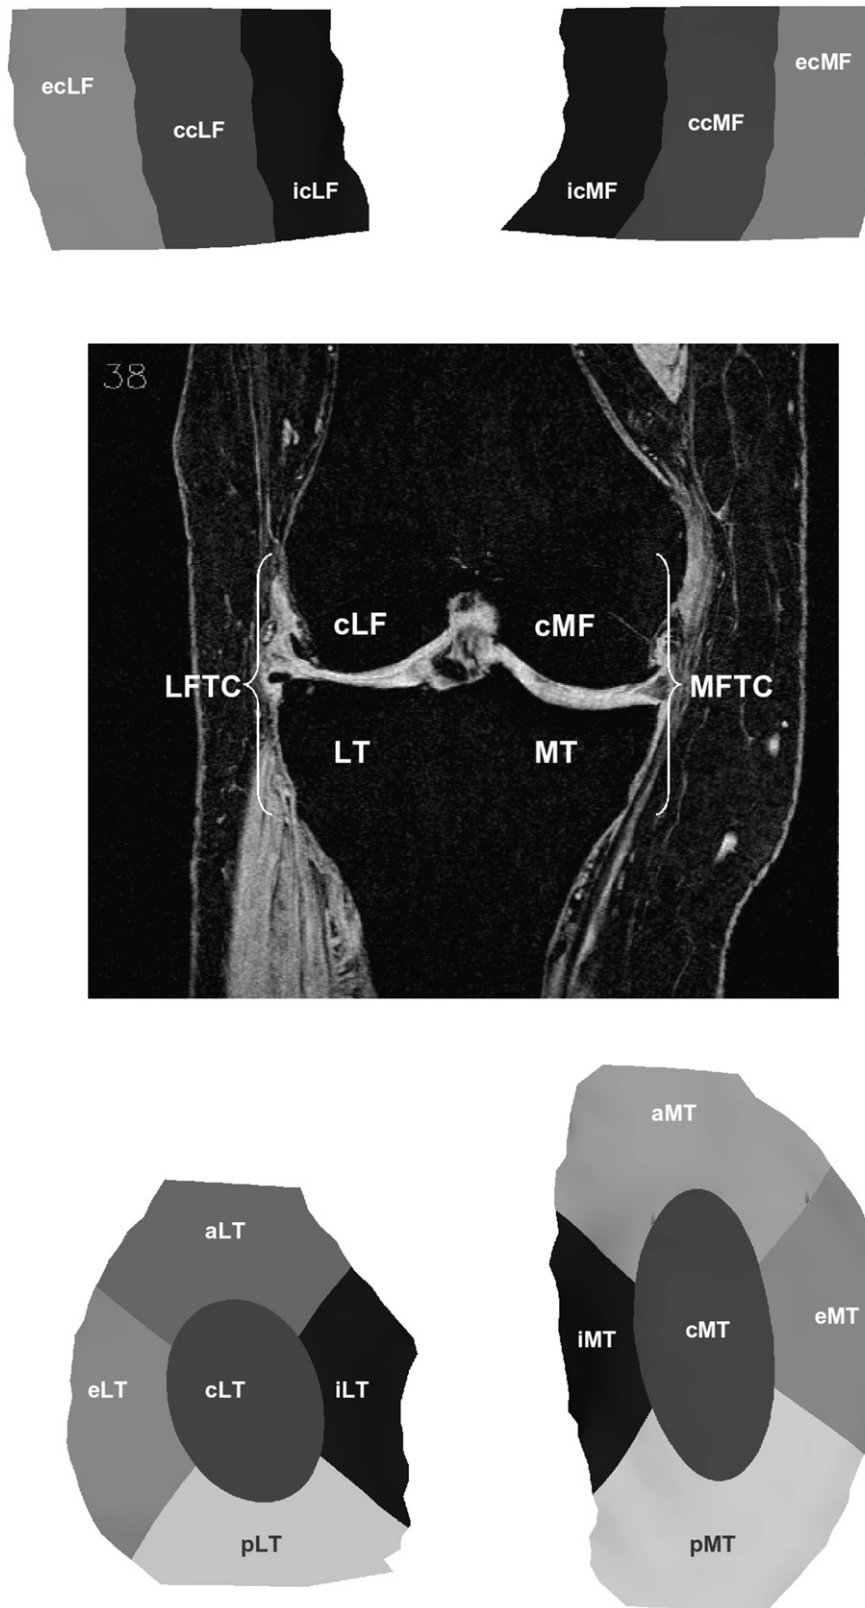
Double oblique coronal fast low angle shot (FLASH) MR image with water excitation showing the regions of interest analyzed: MFTC (=MT + cMF), LFTC (=LT + cLF). The top part of the figures shows a reconstruction of the weight-bearing parts of the femoral condyles (cMF and cLF) and the lower part a reconstruction of the tibiae (MT and LT). (c|e|i|a|p = central|external|internal|anterior|posterior subregion of MT or LT. c|e|i = central|external|internal subregion of the central part of cMF or cLF).
